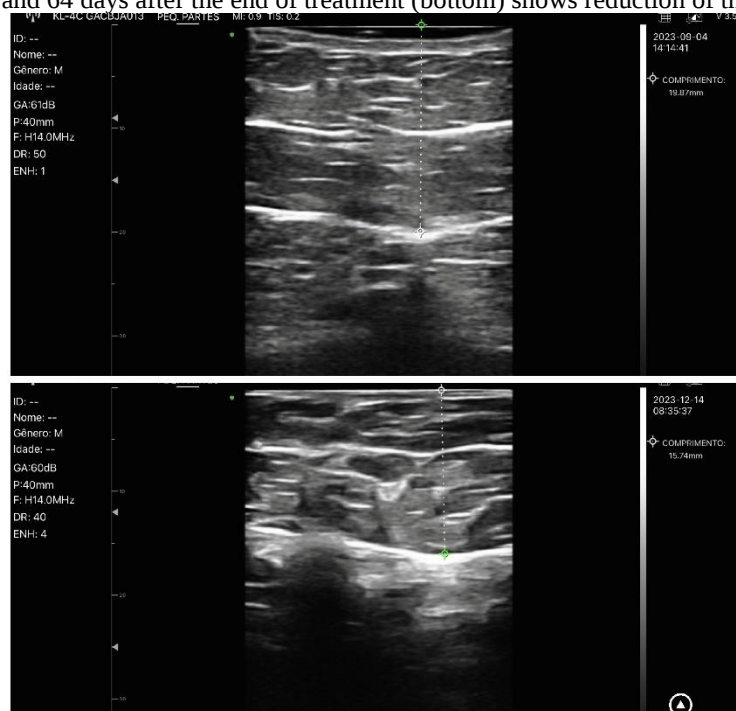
Ultrasound of representative assessment of the thickness of the lower right layer. Fat thickness at baseline (top) and 64 days after the end of treatment (bottom) shows reduction of the adipose layer.
